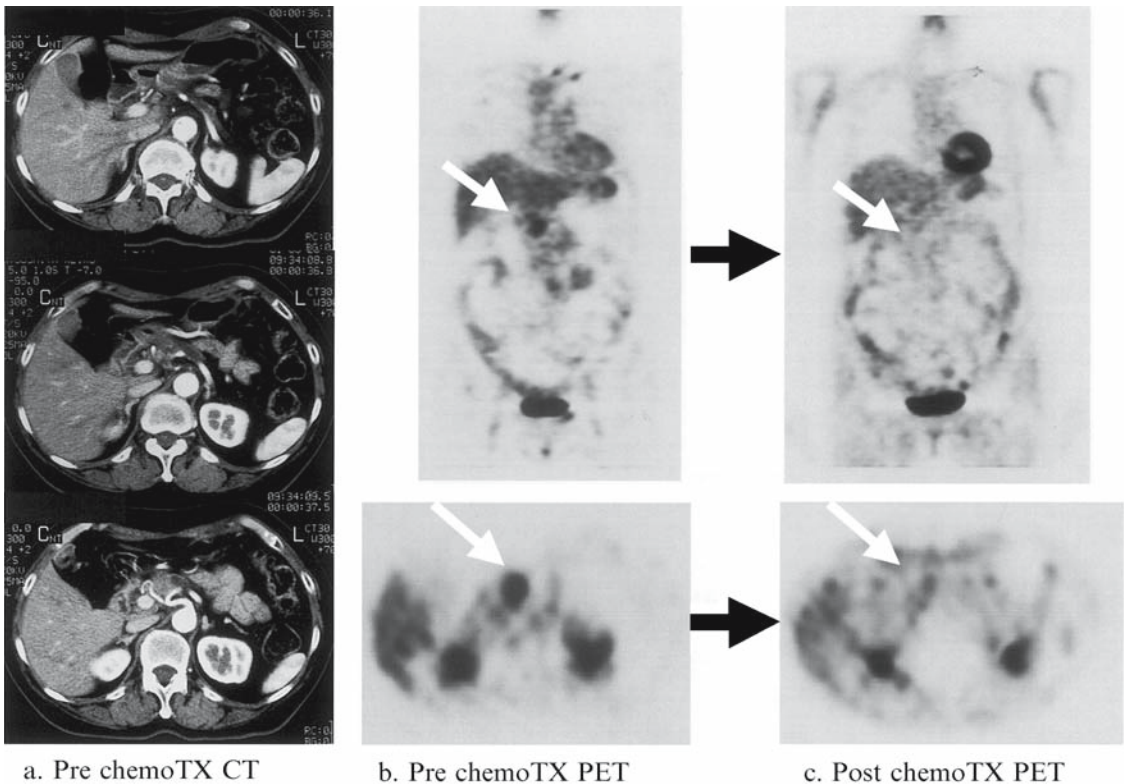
Evaluation of therapeutic effect of chemotherapy using FDG-PET. Sixty-six years old female, 3-years-survivor with pancreatic cancer. (a) CT findings show direct infiltration to the surrounding arteries and retroperitoneal tissues at the time of initial diagnosis. This tumor was diagnosed as unresectable and chemotherapy with weekly-based venous-infusion of gemcitabine was performed. (b) FDG-PET before chemotherapy shows intense uptake in the pancreatic head (white arrow). Semiquantitative analysis revealed that SUV at 1 and 2 h after injection were calculated as 5.4 and 7.3, respectively, with retention index (RI) 36%. High RI means a possibility of long survival. (c) FDG-PET was performed 1 month after the beginning of chemotherapy. The uptake observed before the chemotherapy in the pancreatic head remarkably disappeared (white arrow), although CT findings of cancer did not show any change in shape of the tumor at that time (not shown). Chemotherapy using weekly-based gemcitabine had shown effective therapeutic outcome for 2 years, and then multiple lung metastases were detected finally. *chemoTx*: chemotherapy
